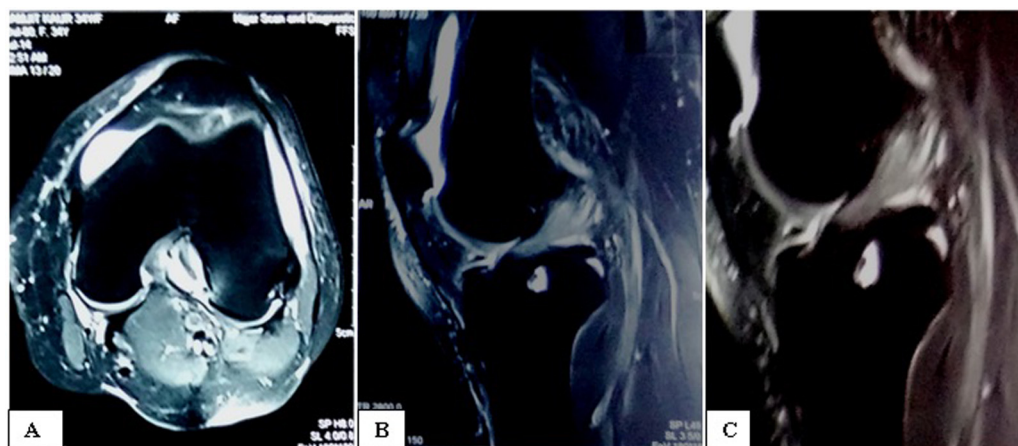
(A–C) Magnetic resonance images showing cyst in the anterior cruciate ligament with preserved fibres with bulky ACL and increased intensity.
